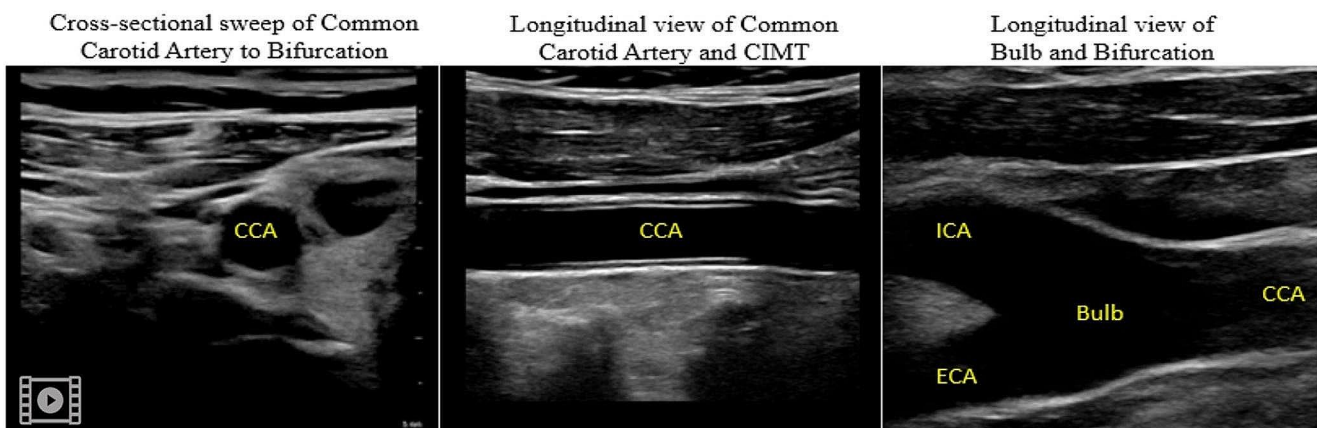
Summary of views with example carotid ultrasound images
